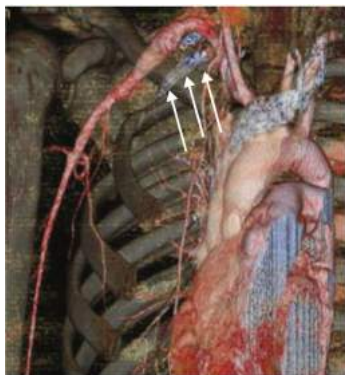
• CT-A reconstruction of 19-year-old collegiate tennis player with cervical rib (arrows) that led to subclavian aneurysm formation. Patient presented with fingertip emboli after playing long matches.
